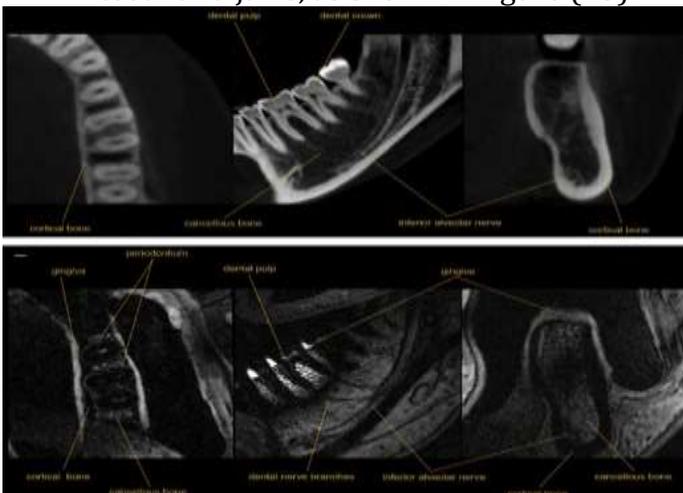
shows imaging for soft tissues surrounded by the tooth by using Magnetic Resonance Imaging (MRI) imaging (Husniye Demirturk et, al. 2018)
